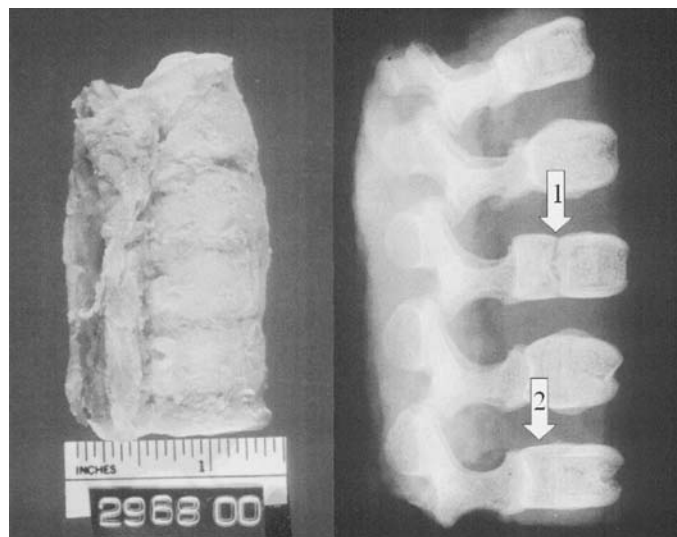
Lumbar vertebrae removed en bloc prior to maceration (left) and corresponding postmortem X-ray revealing a clear defect of the vertebral body of L3 (Arrow 1) and a slight defect in L5 (Arrow 2) (right).
